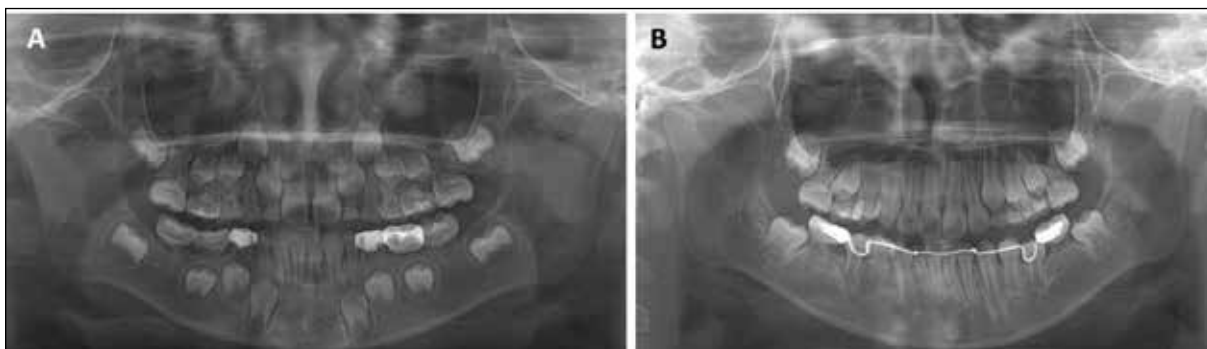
Case 2. (A) Panoramic radiograph of a six-year-old girl with MRIM at the first visit. (B) Two years after installation of the lingual arch, the second premolars replaced the second primary molars.
